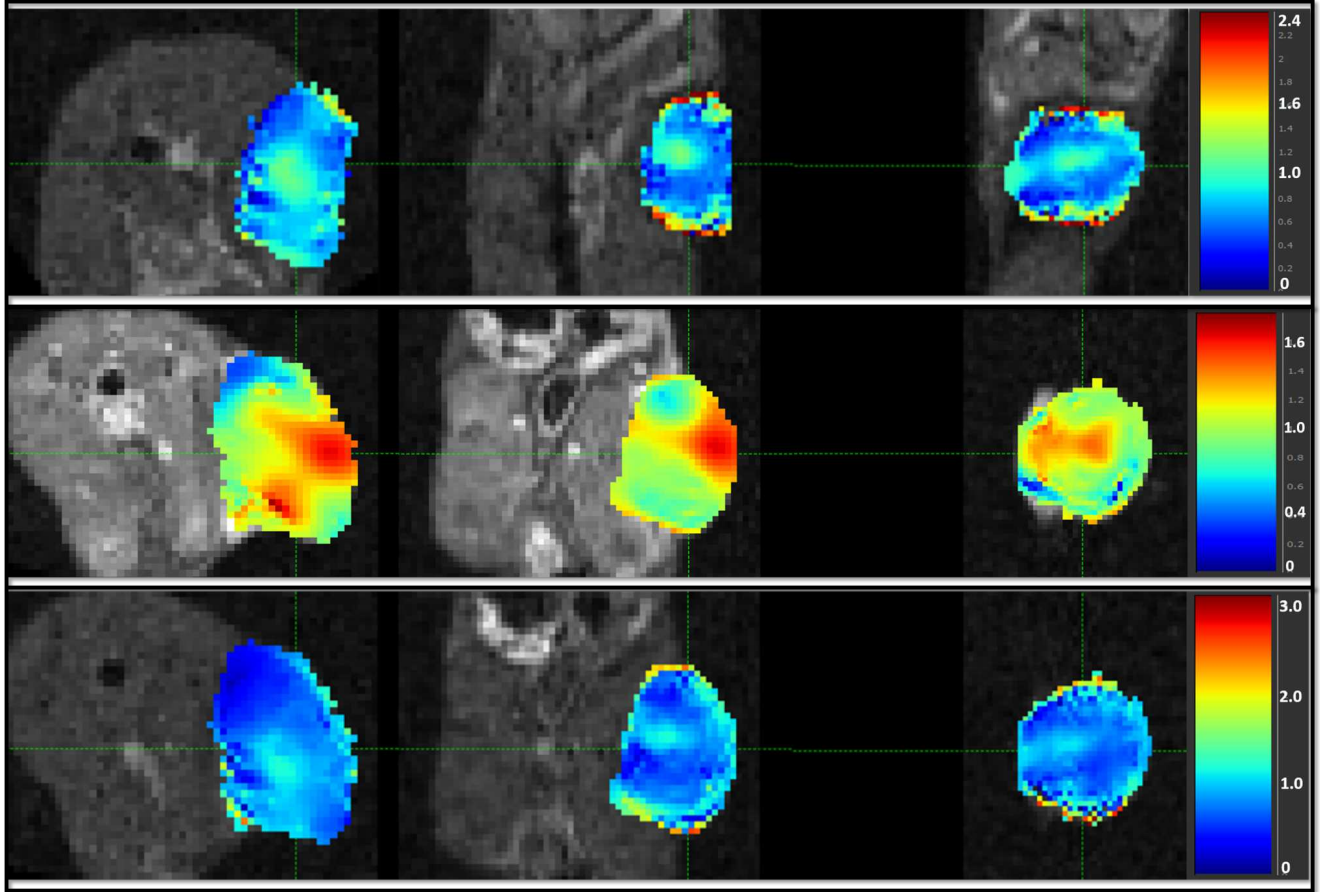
DCE-MRI overlaid with the determinant of the Jacobian of the estimated displacement field obtained using  $cell_h$  as guidance image for the registration between  $\tau_1/\tau_2$  (top row),  $\tau_2/\tau_3$  (middle) and  $\tau_1/\tau_3$  for Case 1. The higher Jacobian values ( $>1$ ) can be mainly observed in the tumor peripheries where the highest level of proliferation and hence growth is expected. Values close to 1 and smaller than 1 representing volume preservation and shrinkage, respectively, can be seen in the inner core of the tumor.
